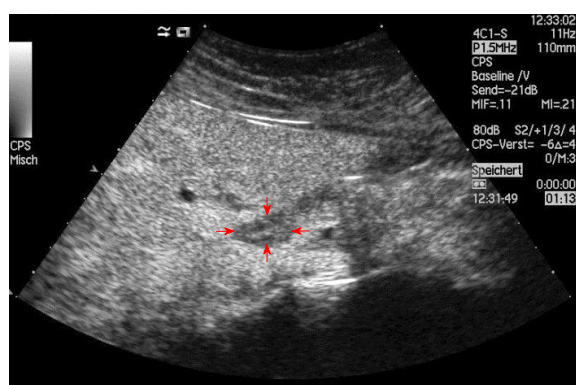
Enlarged perihepatic lymph nodes dorsal in the hepatoduodenal ligament is a typical sonographic sign of autoimmune hepatitis. Contrast enhanced ultrasound shows normal lymph node architecture (in between arrows).
